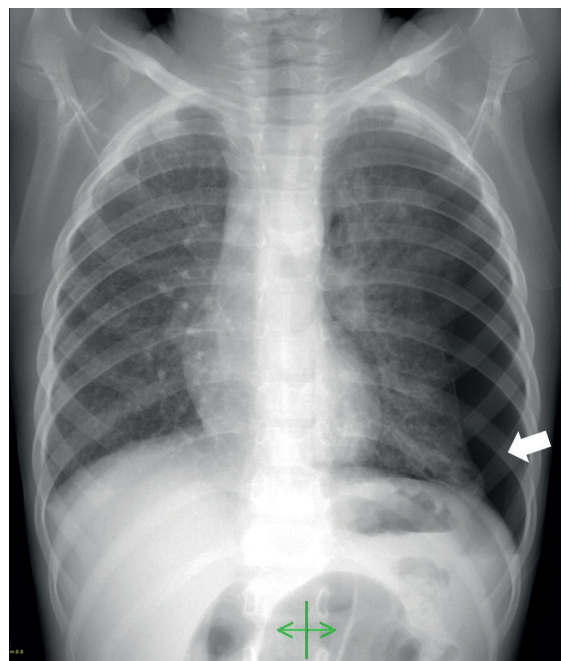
4-year-old boy with Langerhans cell histiocytosis. Posteroanterior chest radiograph shows left sided pneumothorax (arrow). There are widespread cystic changes and diffuse reticulonodular opacities in both lungs.
